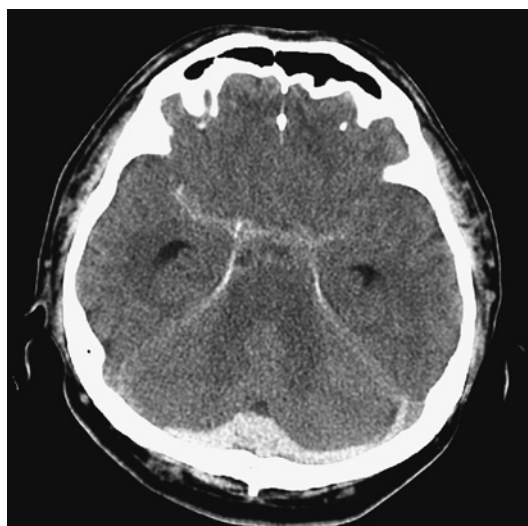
Brain CT showing subarachnoid hemorrhage on the 8th hospital day. There was no aneurism.
